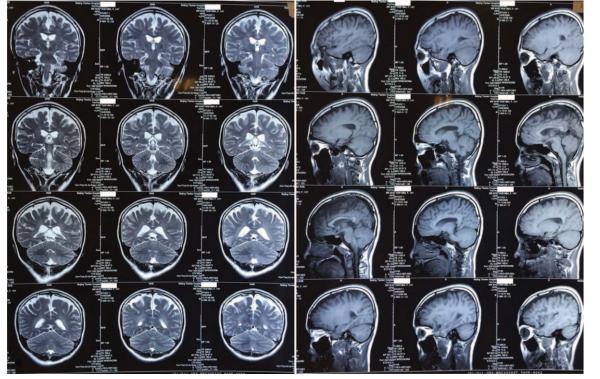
Diffused atrophy in cerebral cortex in magnetic resonance imaging (MRI).
